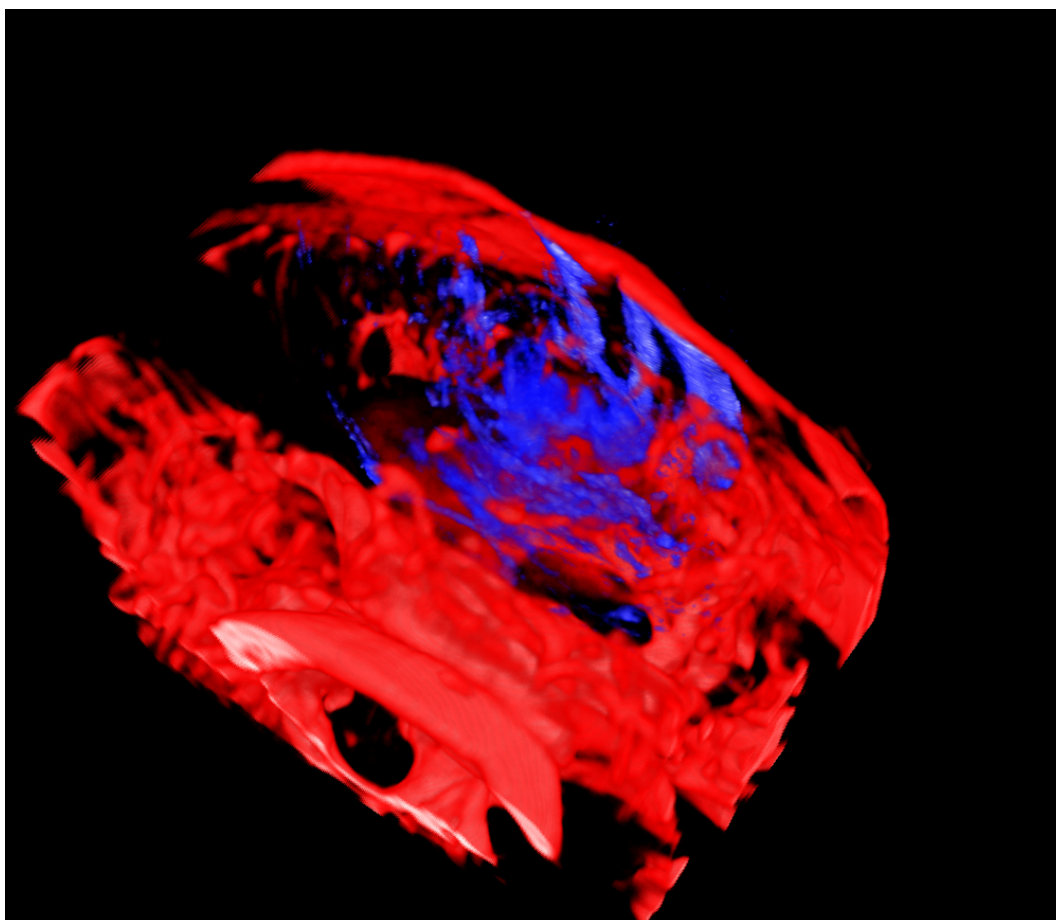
Tumor 1, phase 2. Volume rendering of MRI T2 (*red*) & UST (*blue*) before registration.
